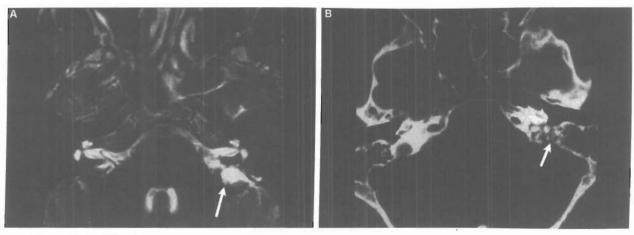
Endolymphatic sac tumor. This 32-year-old female with VHL developed sensorineural hearing loss on the left due to an endolymphatic sac tumor (arrow) on T2-weighted sequence MRI (A). A CT scan (B) of the same lesion demonstrates bony erosions due to the tumor (arrow).
